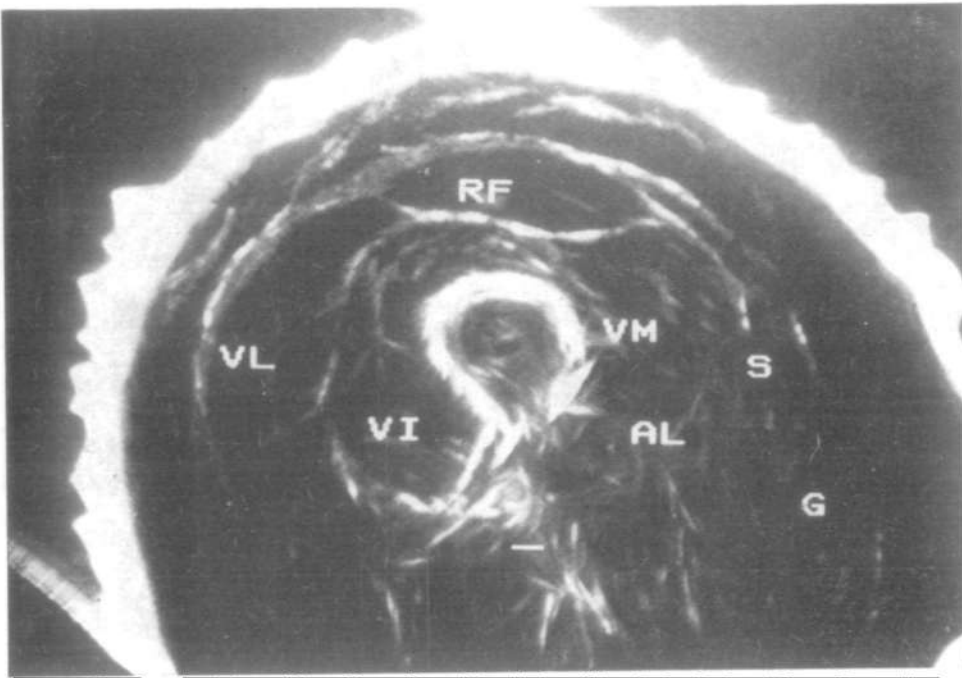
Normal transverse ultrasonogram made at the mid-thigh level in a 19-year-old girl (VI = vastus intermedius; VL = vastus lateralis; RF = rectus femoris; VM = vastus medialis; AL = adductor longus; S = sartorius; G = gracilis).
